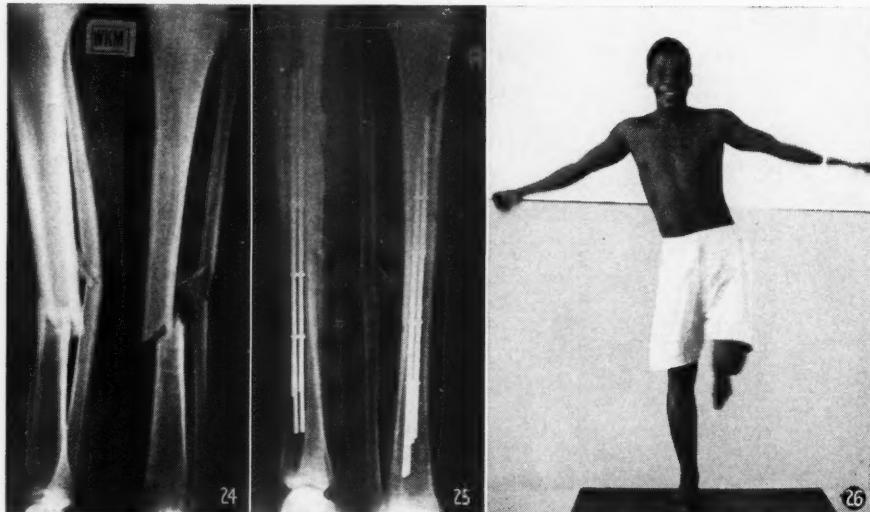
Case No. 5. Pre-operative X-ray.
